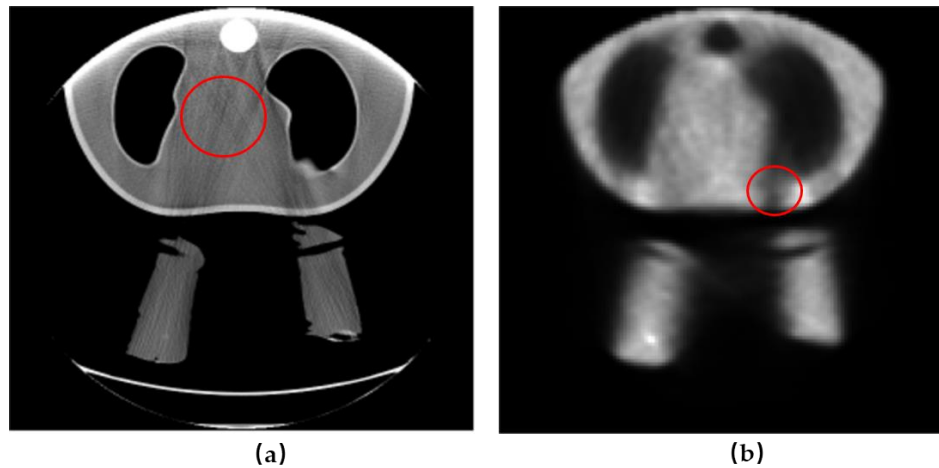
Example of artifacts in (a) CT image and (b) PET image caused by different factors.
